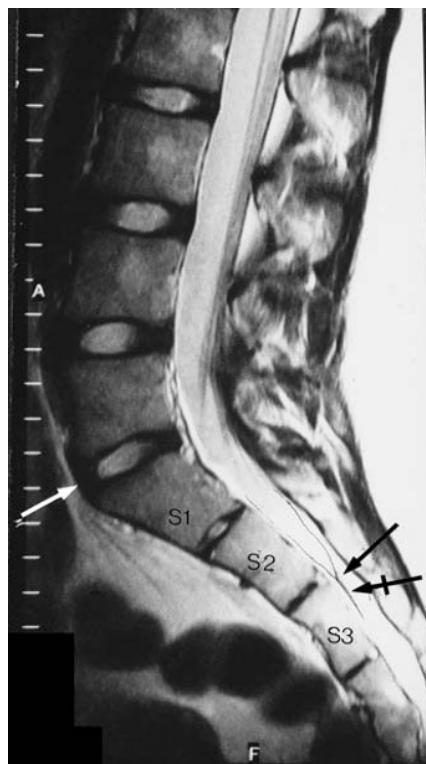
Lumbosacral MRI sagittal T2-weighted image showing the thecal sac extending to the lower S2/upper S3 level (black arrow) with a suggestion of thickening of the filum at this level (tailed arrow). The L5-S1 intervertebral disc level is indicated by the white arrow.
